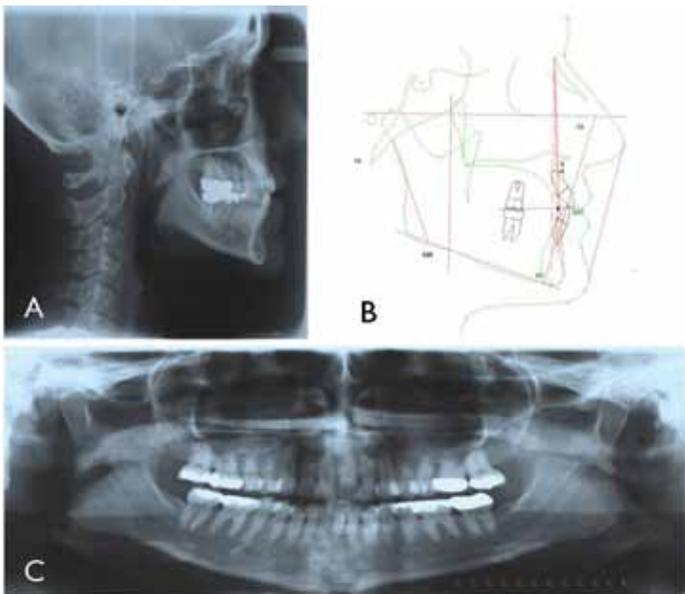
A. Initial Ceph. B. Initial Ceph Tracing. C. Initial Panoramic Radiograph
